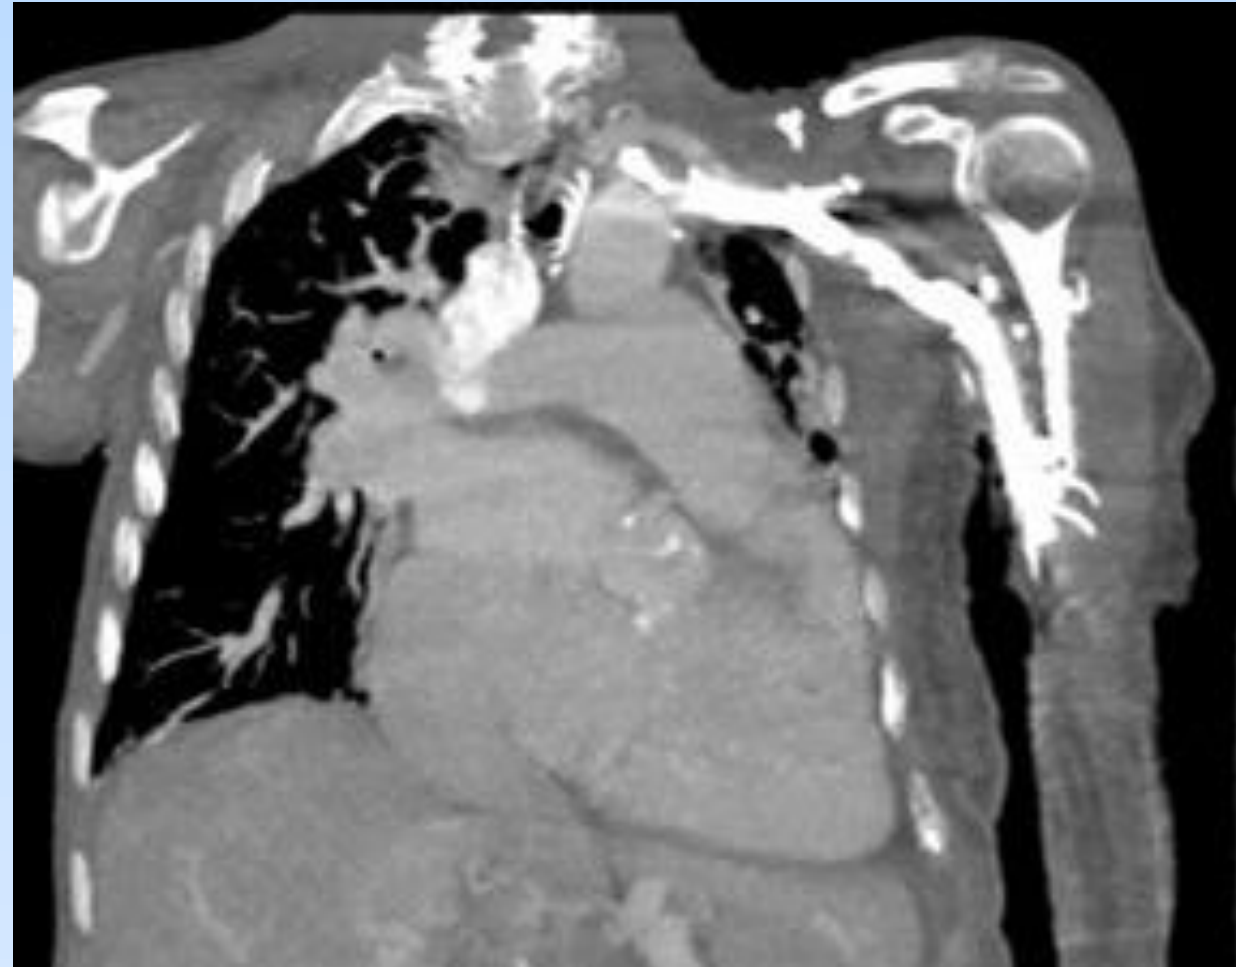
CTA demonstrating enlarged heart
